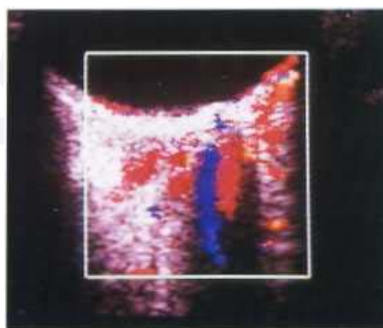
Colour Doppler scan showing normal central retinal artery (red) and vein (blue).
